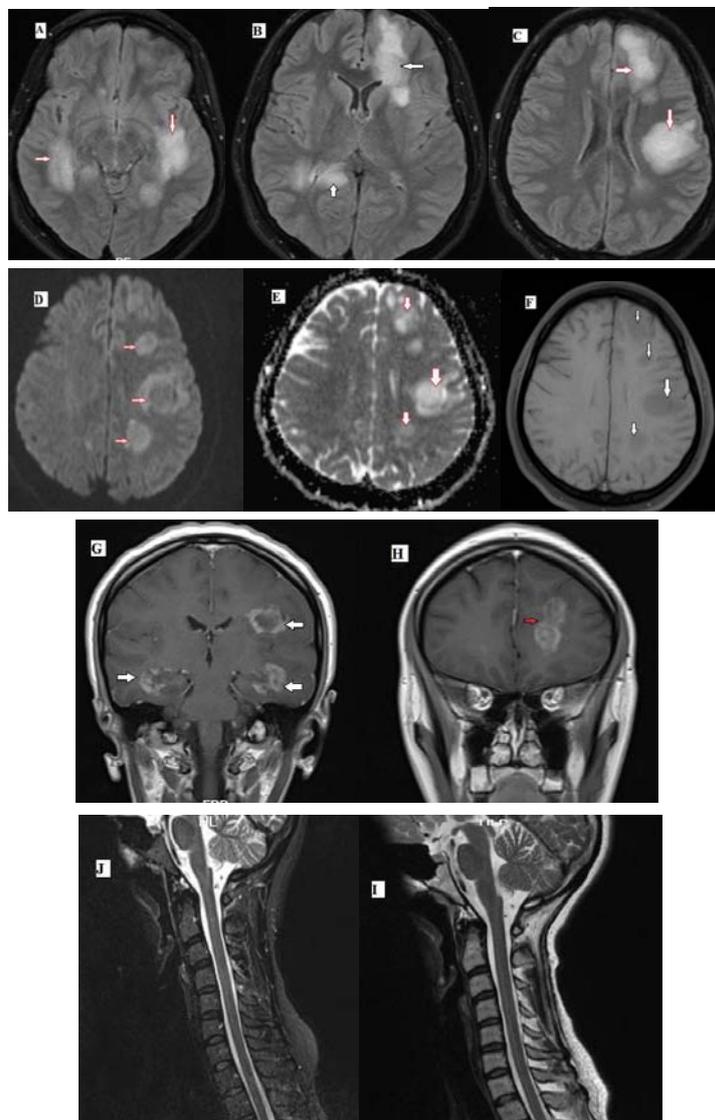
MRI studies on hospitalization. Axial fluid-attenuated inversion recovery (FLAIR, A-C, arrows) MRI of the brain shows multifocal areas of hyperintensity in both cerebral hemispheres involving bilateral medial temporal lobe and sylvian fissure, left centrum semiovale gray matter, right splenium of corpus callosum, while T1-W (F) shows low signals in left centrum semiovale gray matter. The diffusion-weighted image shows the lesions in the left centrum semiovale to be mildly hyperintense (arrow) without areas of restricted diffusion on Apparent Diffusion Coefficient (ADC) (D-E). Postgadolinium (Gd) T1-weighted (T1w) sequence of the brain in the coronal plane showing enhancing lesions (arrows) (G-H). Cervical MRI shows no significant change on Sagittal T2-weighted and FLAIR images (I-J).
